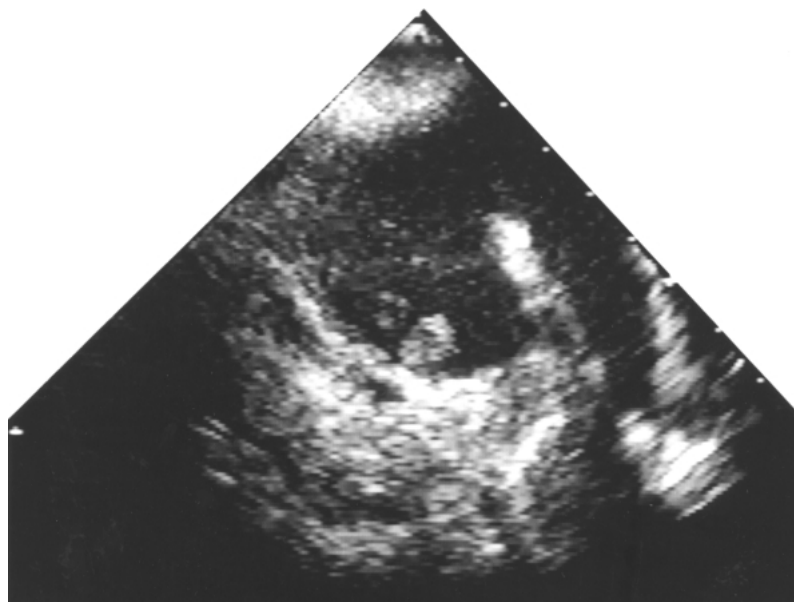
Transesophageal echocardiograph of the case patient on hospital day 3. A new left atrial thrombus is noted, inferior to the left atrial appendage and superior to the posteromedial leaflet of the mitral valve.
